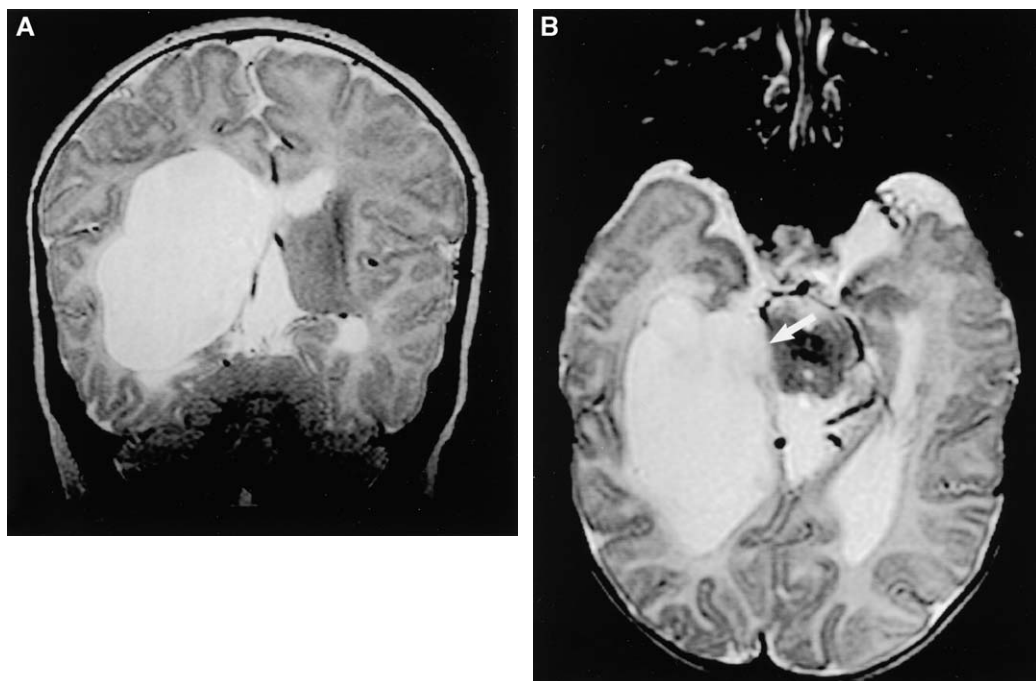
Intraventricular arachnoid cyst. (A) Coronal T2-weighted image demonstrates a large trigonal arachnoid cyst. (B) Axial T2-weighted image demonstrates involvement of the perimesencephalic cistern via the choroidal fissure (arrow), indicating a secondary rather than primary arachnoid cyst.
